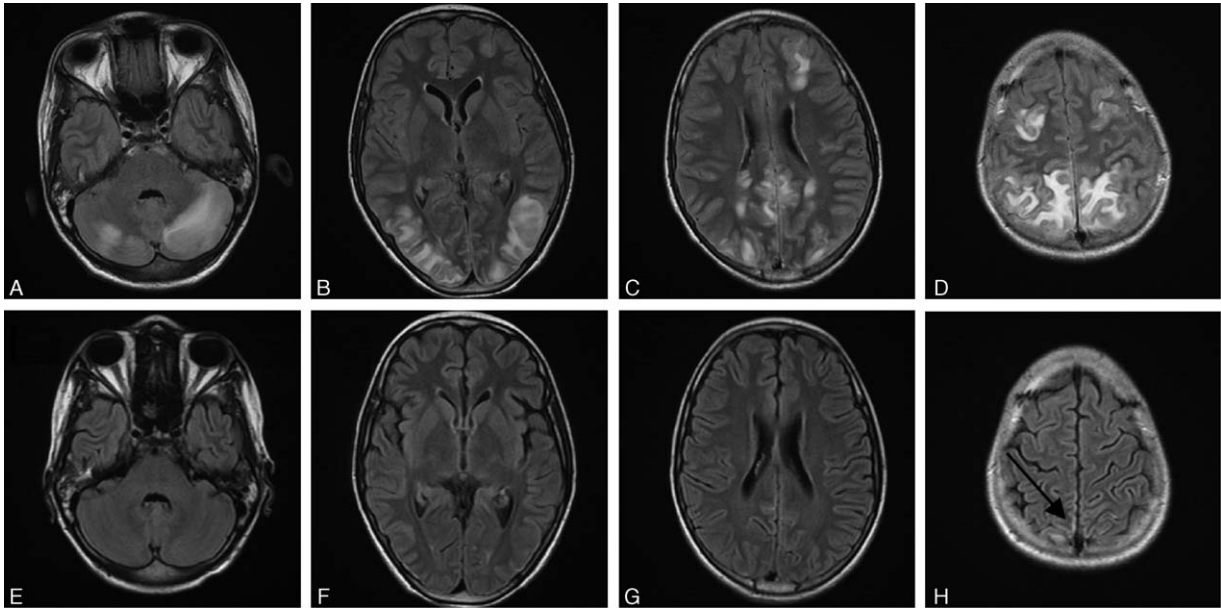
Magnetic resonance (MR) findings. Panels A–D: At the time of diagnosis, axial FLAIR images demonstrated multiple, bilateral areas of hyperintensity and edema in cerebellar hemispheres and temporo-parieto-occipital lobes with cortico-subcortical distribution and predominant white matter involvement. Smaller similar foci were present in bilateral frontal and right posterior periventricular white matter. Panels E–H: 50 days later, axial FLAIR images demonstrated complete regression of edema and signal alteration in both cerebellar and cerebral hemispheric white matter. MR showed marked improvement with only small foci of cortical hyperintensity and thinning in parietal parasagittal regions (Panel H, black arrow).
